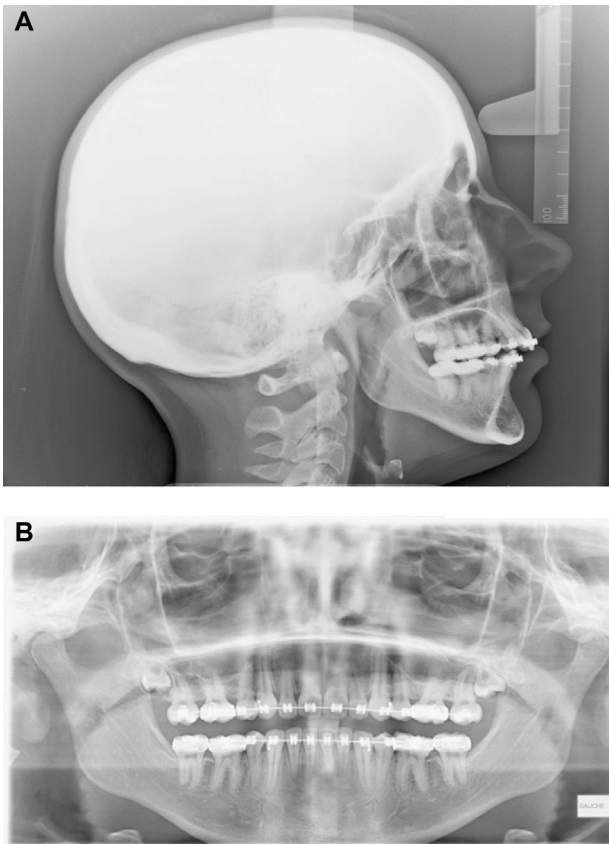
A Preoperative lateral cephalometric radiograph of the patient, showing a
